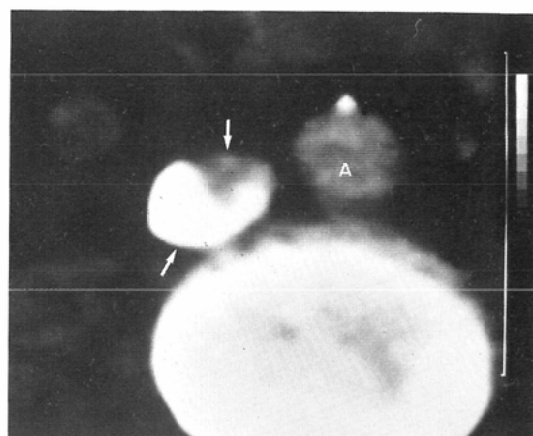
Case No. 1, A 40 year-old male. A magnified view of CT scan with bolus injection in the foot vein. This demonstrated "layered" pattern of opacified IVC, and shows three layered at full-inspiration. Arrow: IVC, A: aorta
